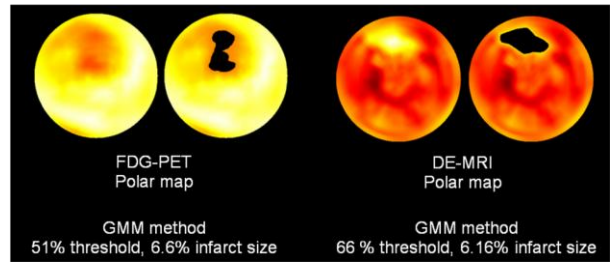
PET and MRI polar map, GMM threshold value is 51% and 66%, infarct size is 6.6% and 6.16%, respectively
